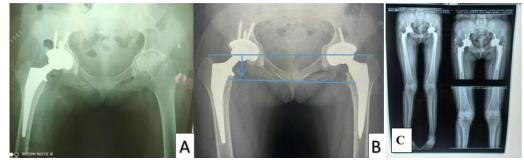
(A) Plain X-rays AP view showing right THA. (B) Plain X-rays AP view showing bilateral THA. (C) Long-standing CT sonogram showing LLD of 0 cm after bilateral THR.
